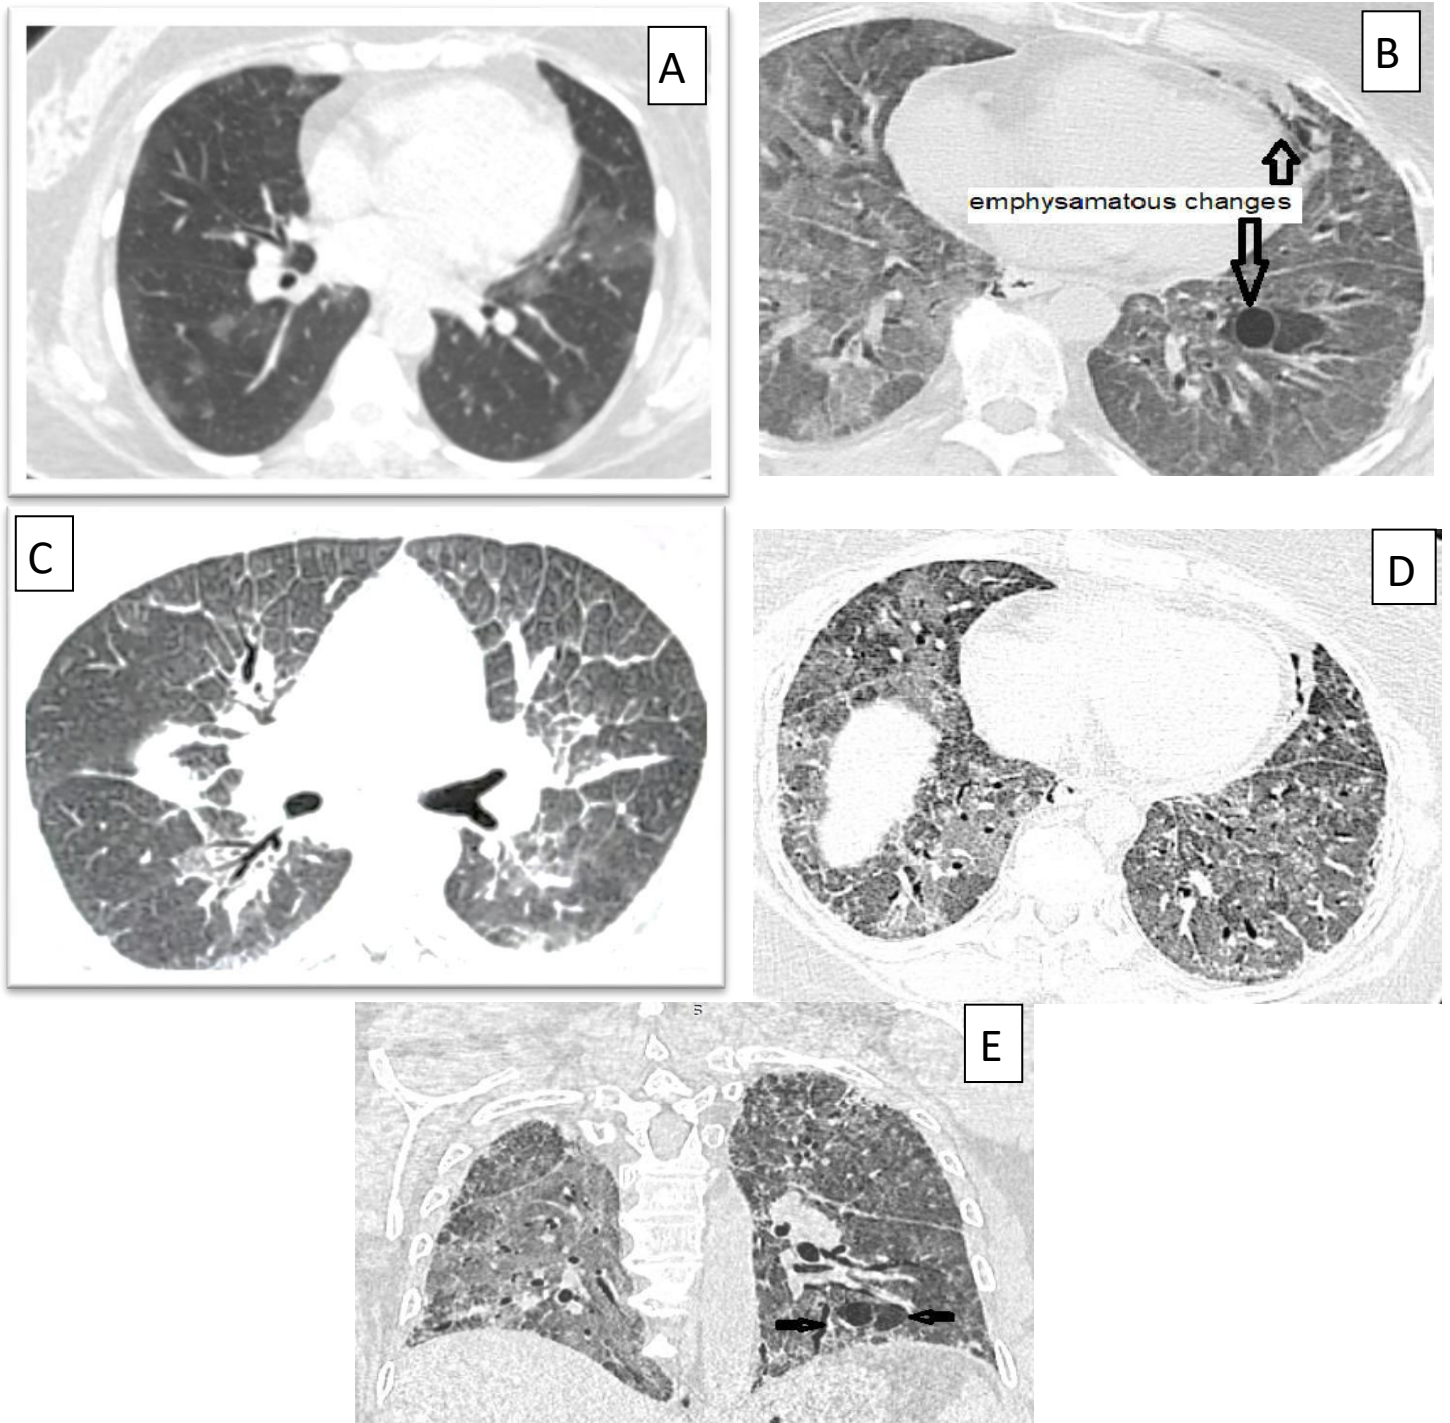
67 old female with COPD first presented with fever and cough; first CT was done showing classic COVID-19 patches, CT-SS 10/25 (A) & some emphysematous
